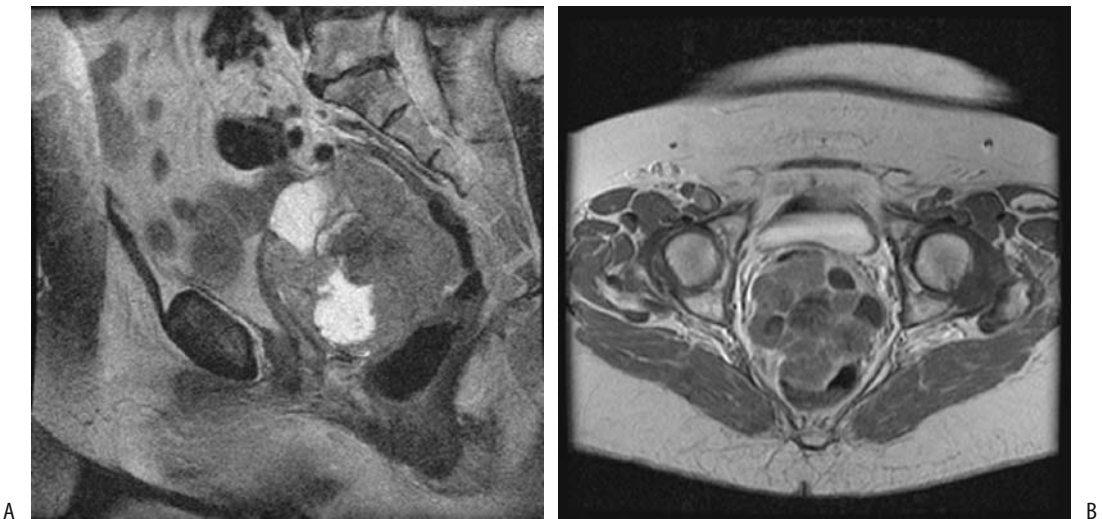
Fallopian tube adenocarcinoma in a 76-year-old woman. A: Sagittal FSE T2-weighted MR image identifies a pelvic mass containing heterogeneous signal intensity. This tumor was in the cul-de-sac, compressed the rectosigmoid colon, and was adherent to small bowel. B: Transverse postcontrast T1-weighted MR image shows peripheral tumor enhancement with extensive non-enhancing regions of necrosis. (Source: Szklaruk J, Tamm EP, Choi H, Varavithya V. MR imaging of common and uncommon large pelvic masses. *RadioGraphics* 2003;23:403–424, with permission from the Radiological Society of North America.)
